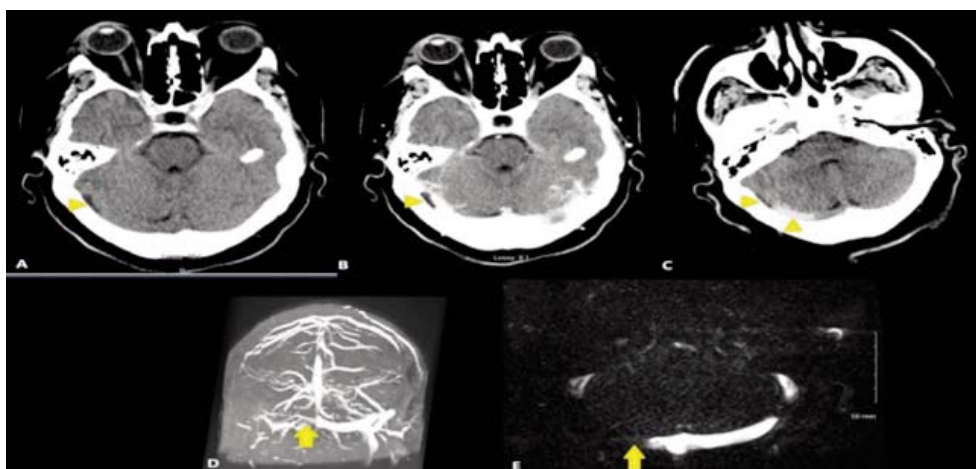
Images of head CT (computed tomography) and MRI (magnetic resonance imaging) demonstrating right transverse sinus thrombosis in our patient. (A) CT head without contrast demonstrating a hypodensity in the expected location of the right transverse sinus (arrowhead). (B) and (C) CT head with contrast demonstrating a filling defect within the right transverse sinus (arrowheads). (D) and (E) MRV (magnetic resonance venography) images show non-visualization of the right transverse sinus (arrows), concordant with CT findings, and confirming right transverse sinus thrombosis.
